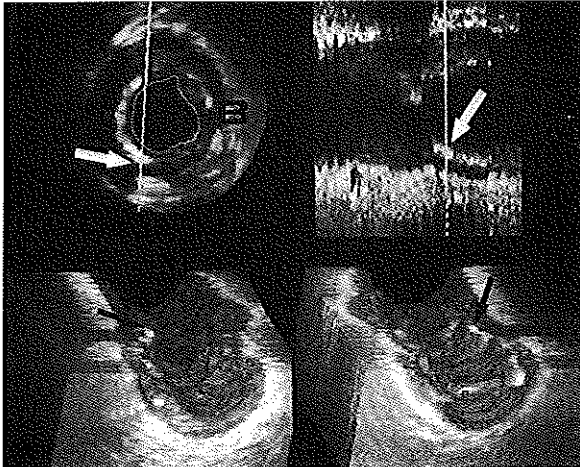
Complex coronary lesion in a mid right coronary artery before intervention. A large superficial calcification (arrowheads) is visible in the transverse (left upper panel), the longitudinally reconstructed (right upper panel), and the cylindrical view (lower panel). Segmentation is performed by acoustic quantification (EchoQuant, Indec, Capitola, CA, U.S.A.) which detects and consecutively removes the blood-pool (B) from the intracoronary ultrasound images. The length of the plaque calcification can easily be evaluated in the longitudinal reconstruction. The cursors (lines) in the transverse and longitudinal view permit the rotation of the longitudinal reconstruction and the selection of specific cross-sectional intracoronary ultrasound images.
